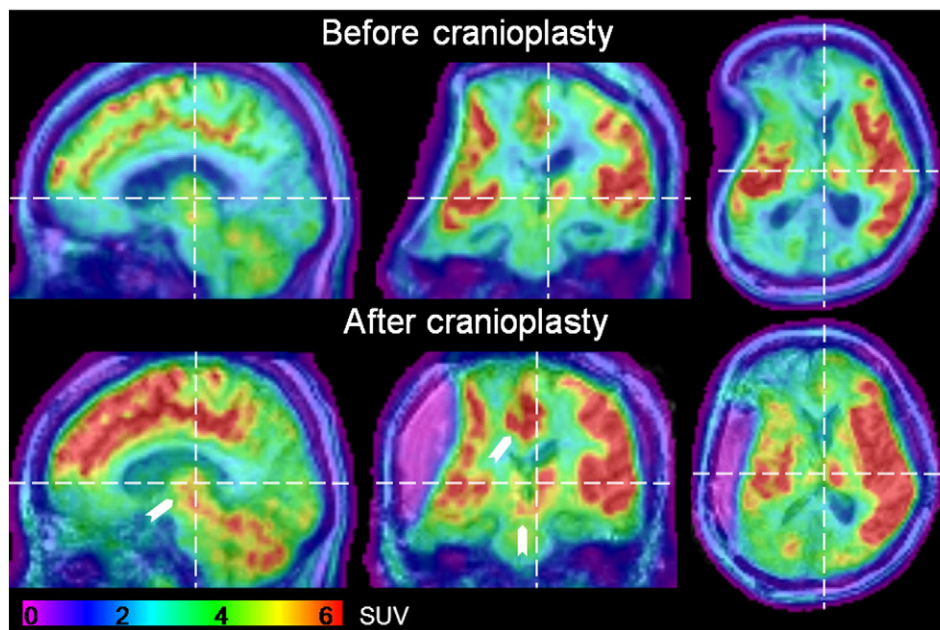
FDG-PET images before and after cranioplasty overlaid onto anatomical MRI images. Color-coded SUVs in units of grams per milliliter as shown in the color bar at the bottom of the panel and arrows point toward changes in the mesodiencephalic and mesial cortical regions. Dashed lines mark the position of the corresponding other cuts. Axial and coronal cuts are shown in radiological convention.
